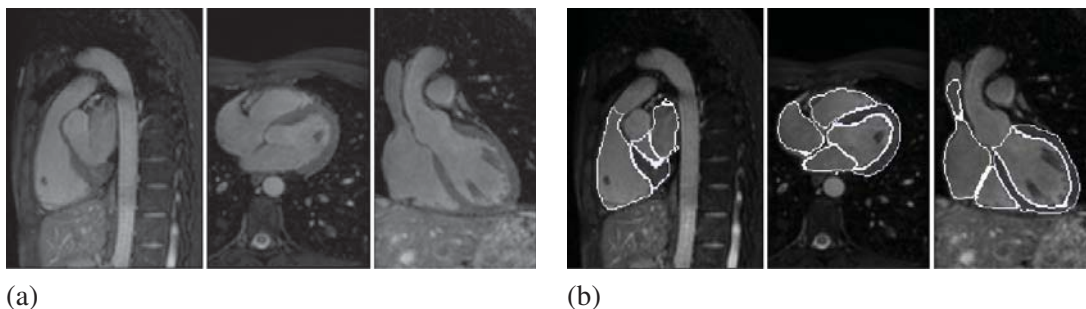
Example of an MR image (a) and its manually delineated surfaces (b). Images shown in sagittal, axial, and coronal views.
